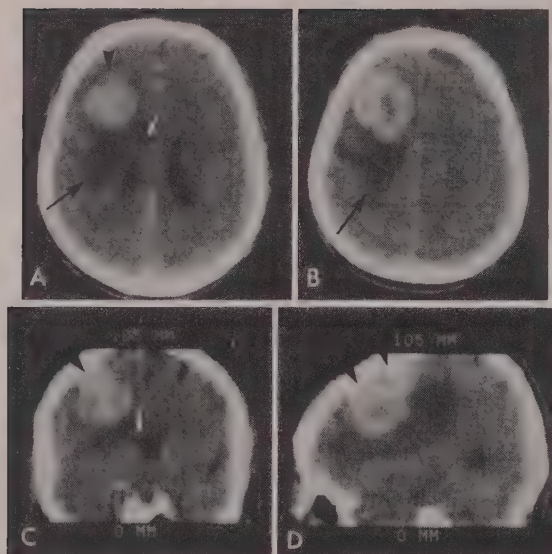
Computer-generated coronal and sagittal reconstructions from a 53 year old man with metastatic epidermoid carcinoma. Courtesy of Dr. Joseph Dooley, St. Louis, Missouri. A and B, CECT scans. Two images from the series of axial sections reveal compression of the left lateral ventricle (white arrow) by a large, intensely enhancing left posterior frontal mass (arrowhead), with significant surrounding lucent edema (black arrows). C, Coronal section CECT generated by the computer from the entire series of axial section CT scans. The mass (arrowhead) extends to the cortex and inner table, is associated with significant subjacent edema, and displaces the left frontal horn (white arrow) inferiorly and to the right. D, Sagittal section CECT generated by the computer from the series of axial section CECT scans. Anterior is to the reader's left. A large portion of the mass lies along the cerebral cortex (arrowheads). Nearly the entire deep surface is outlined by lucent cerebral edema. Sagittal and coronal reconstructions aid understanding of the exact relationship of a mass to all the important structures surrounding it.
